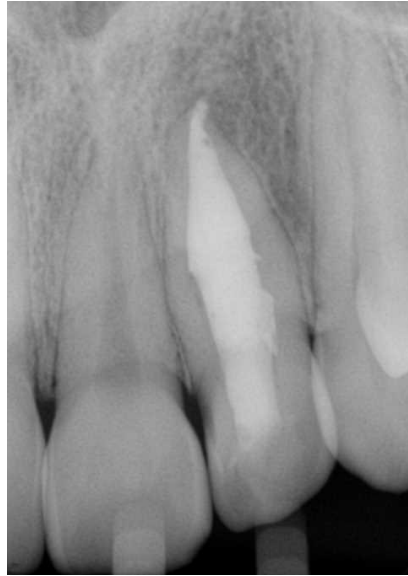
Radiographic follow-up after 14 months
